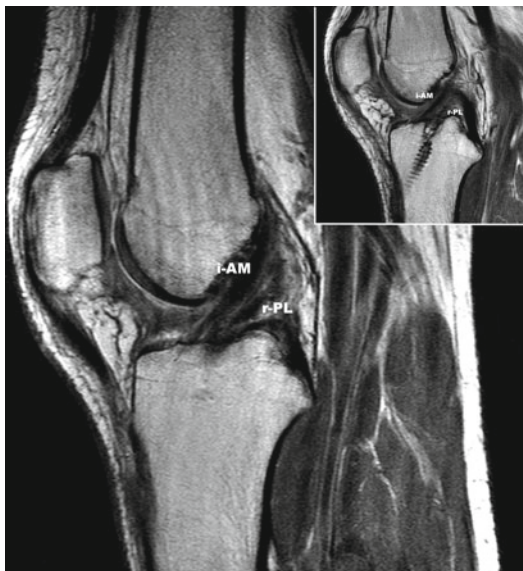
Sagittal views of MRI with a posterolateral bundle reconstructed 6 months before. In these two images, the reconstructed posterolateral bundle as well as the intact anteromedial bundle is clearly seen (*i-AM* intact anteromedial bundle, *r-PL* reconstructed posterolateral bundle)
